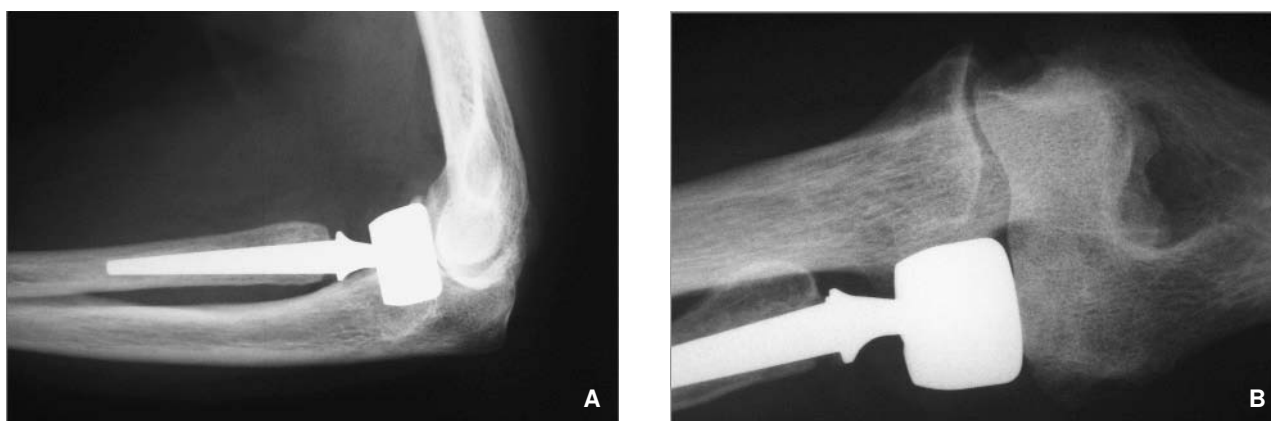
Patient 2. (A, B) The radial head is lengthened if we take the coronoid process as a reference. (B) The radiograph shows osteoporosis in the capitellum and a reduction of the radiocapitellar space.
